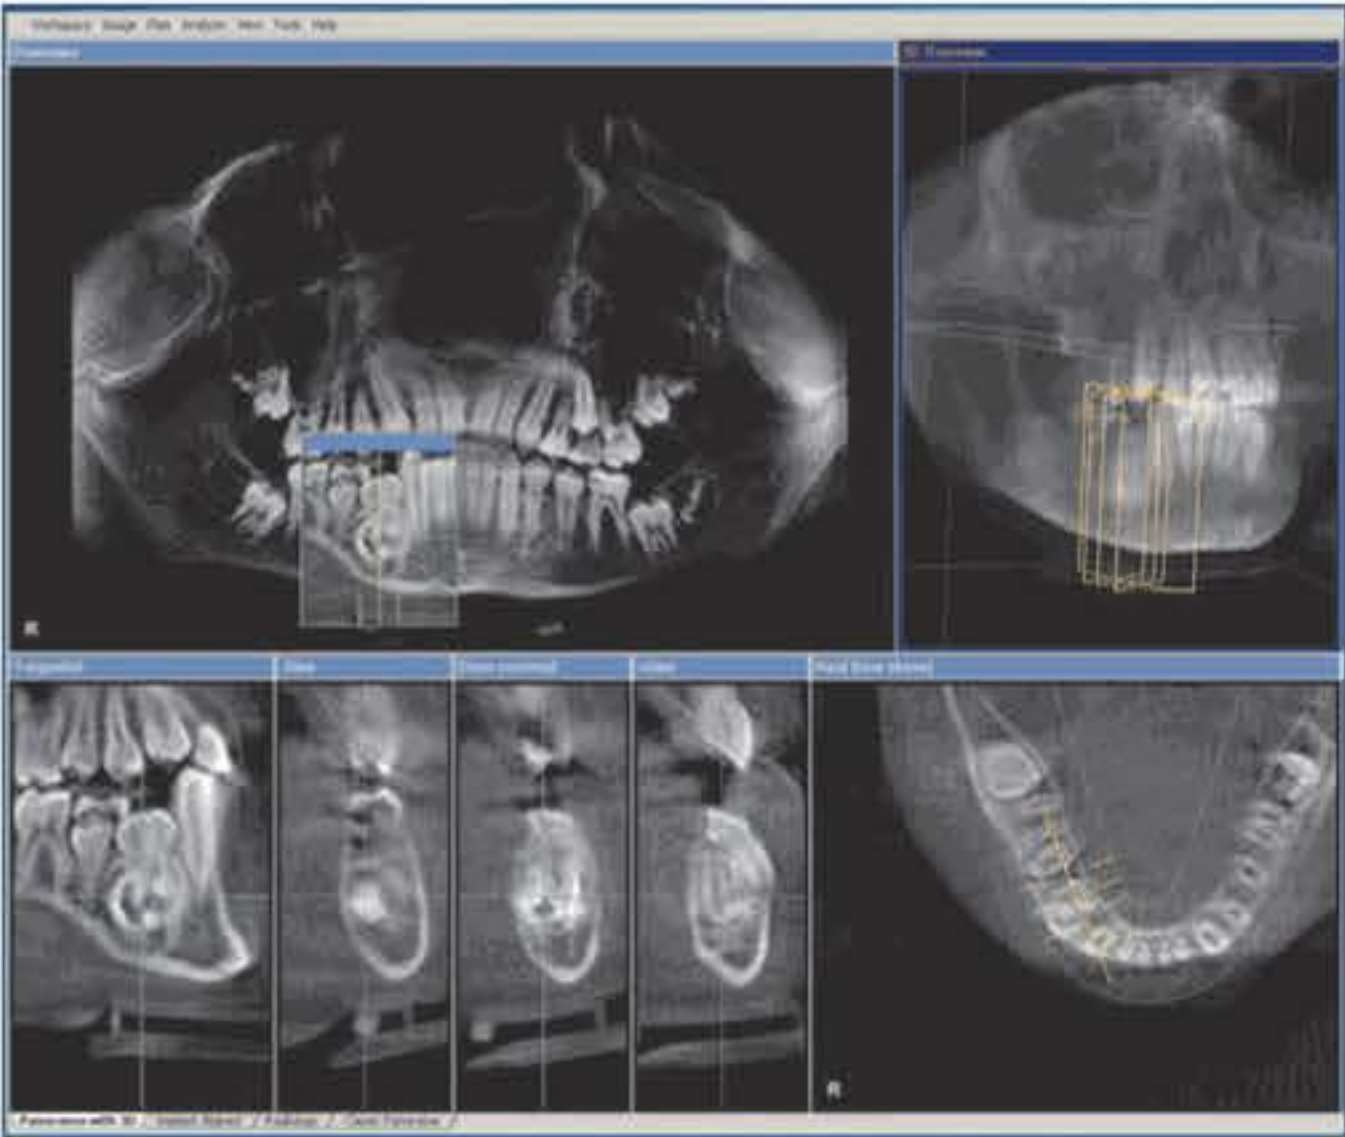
Cone-beam volumetric imaging shows a roundish, calcified mass with a lucent border in the mixed dentition of a 10-year-old male. Tooth 44 was vital and was displaced lingually by the complex odontoma.
